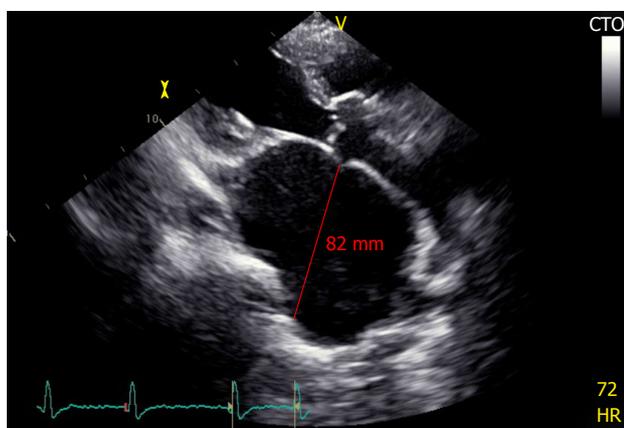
Modified parasternal long axis view in B-mode showing the dimension of the giant left atrium (82 mm).
